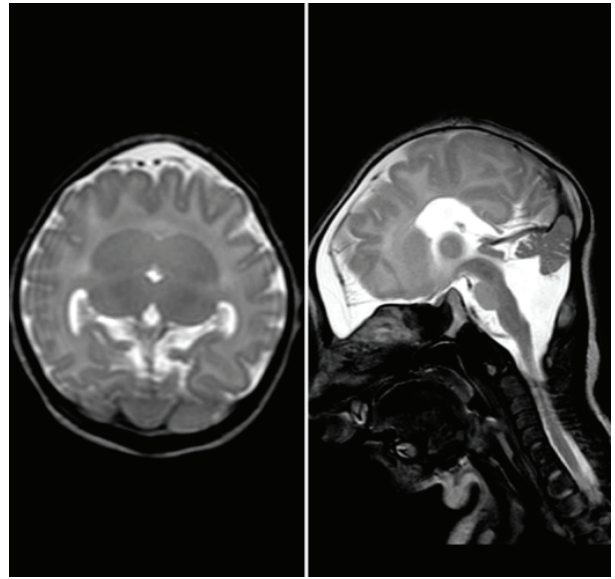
Cranial magnetic resonance imaging sections (holoprosencephaly and corpus callosum agenesis)
